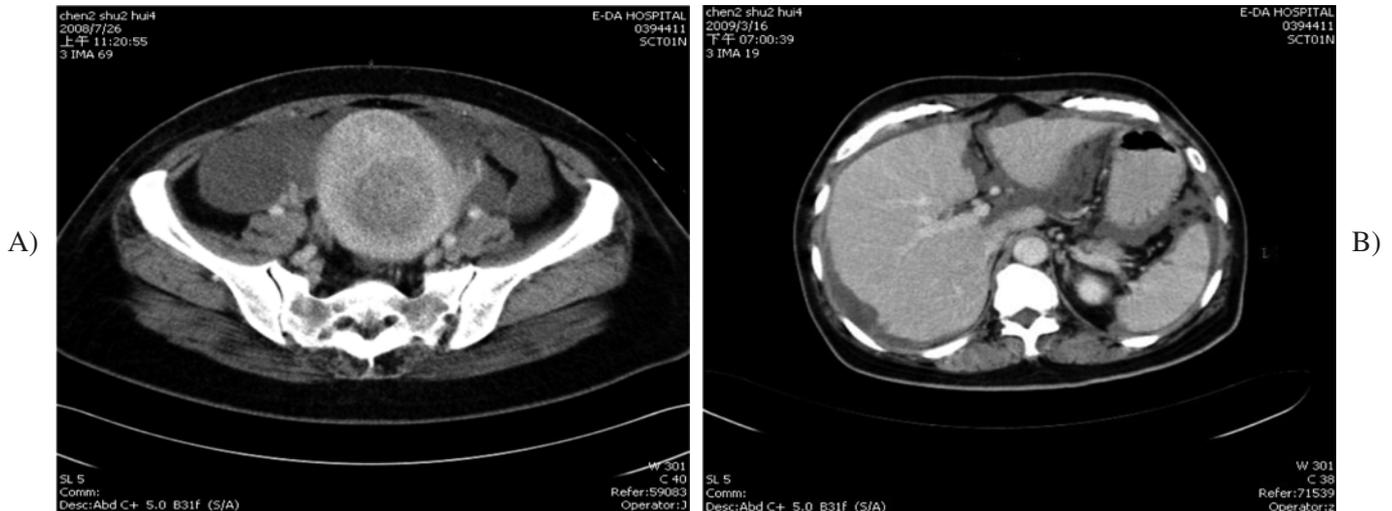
Initial abdominal CT scan showed loculated ascites in the right lower abdomen with septum and small soft tissue density. An enlarged uterus with a 7.7 cm hypodense mass was found with the heterogeneously enhanced mass (A). Seven months later, CT scan showed a heterogeneously enhanced mass about 7.4 cm in diameter over the uterus, size unchanged from the previous CT study. Loculated ascites with an omental caking appearance and indentation of liver surface is noted, which is in favor of peritoneal pseudomyxoma (B).
